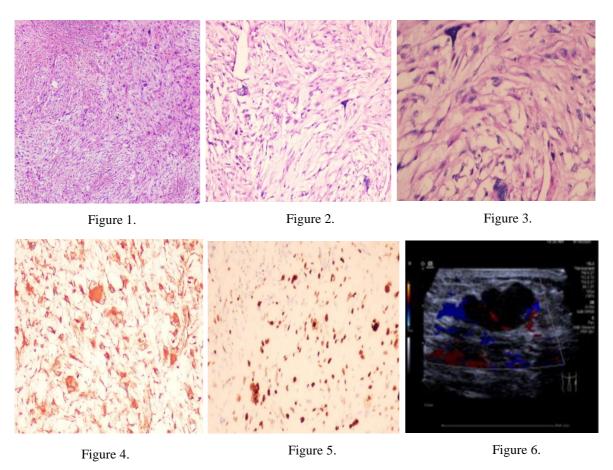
HE×40 showed pleomorphic and spindle tumor cells with unoriented arrangement; Figure 2: HE×100; Figure 3: HE×200 showed multinucleated tumor giant cells,more mitotic images are shown in; Figure 4: IHC×100 Vimentin (+); Figure 5: IHC×100 Ki-67 (about 40% active area); Figure 6: Color ultrasound of body surface mass.
